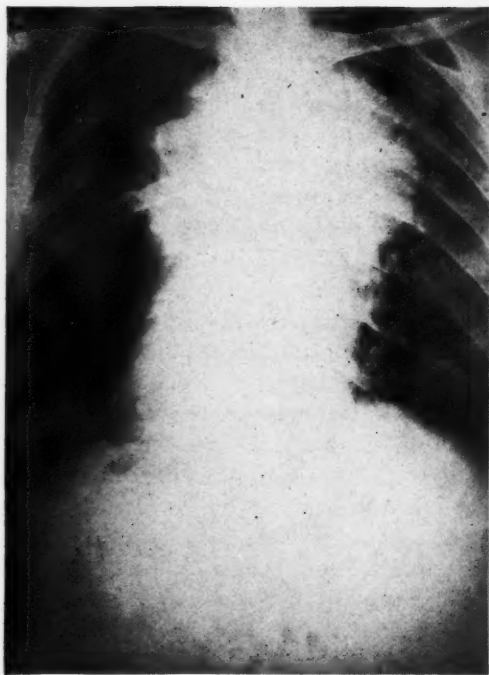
Case 1. Large rounded tumor shadow before X-ray therapy (Aug. 9, 1924).
